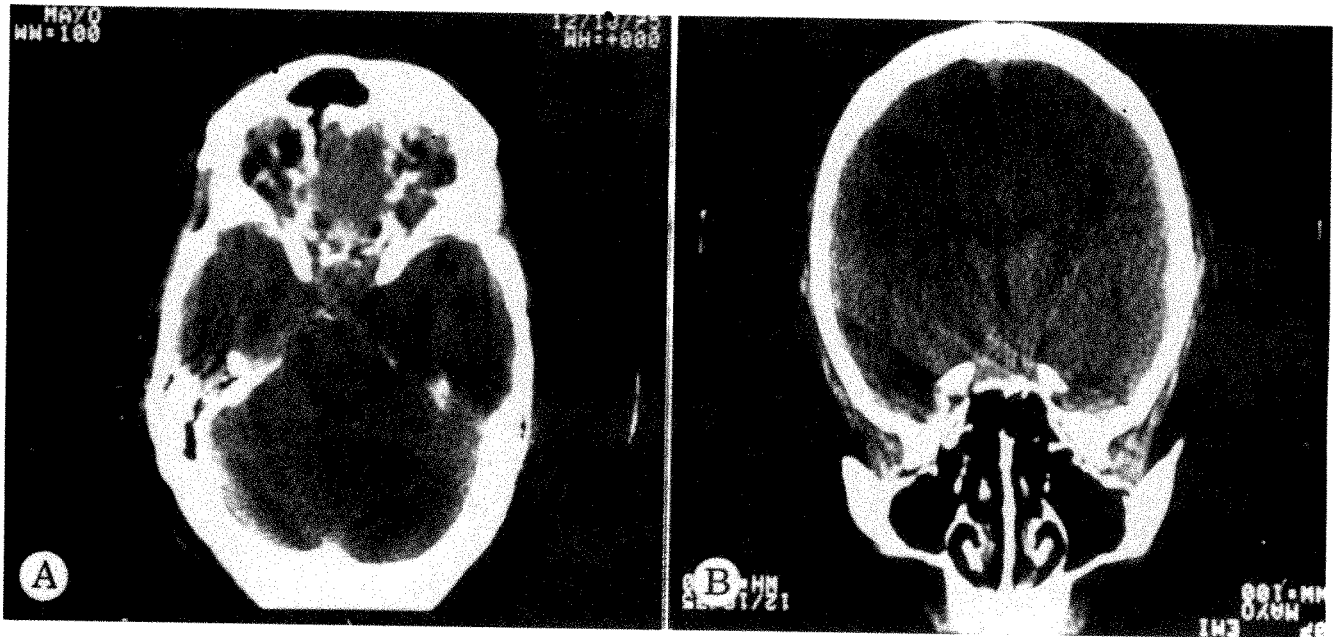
CT scans of patient with large pituitary tumor. *A*, Horizontal section through sella. *B*, Coronal section showing suprasellar extension of pituitary tumor.
